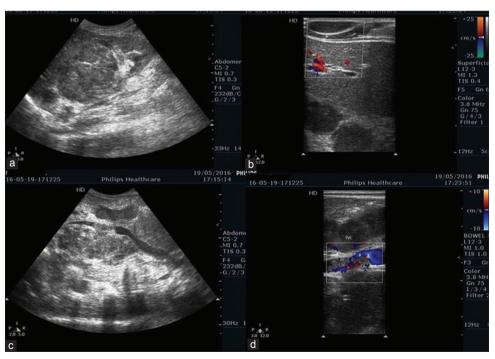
Ultrasonography showing a right renal mass arising from upper and mid pole (a), subcutaneous nodule (b) and tumor thrombus in inferior vena cava (c and d)
